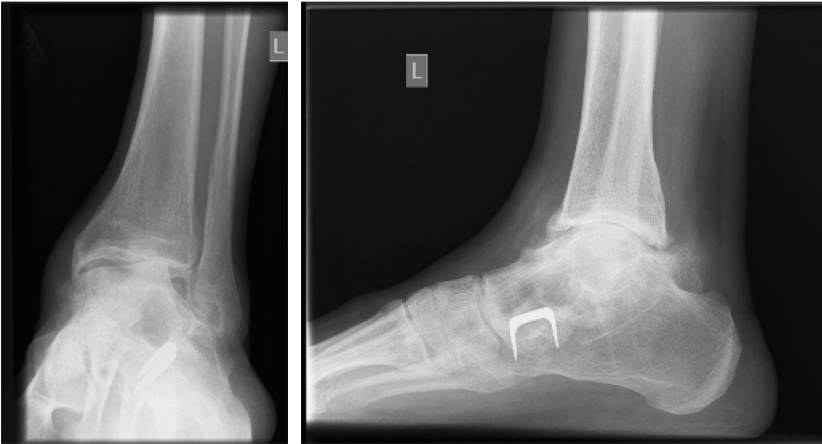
Weight-bearing AP/lateral x-rays showing marked ankle valgus and arthrosis in a 65-year-old male with a remote history of triple arthrodesis at age 12.
